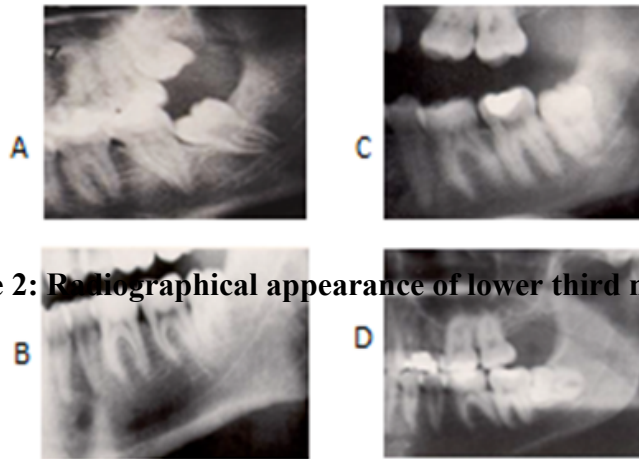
Radiographical appearance of lower third molar
